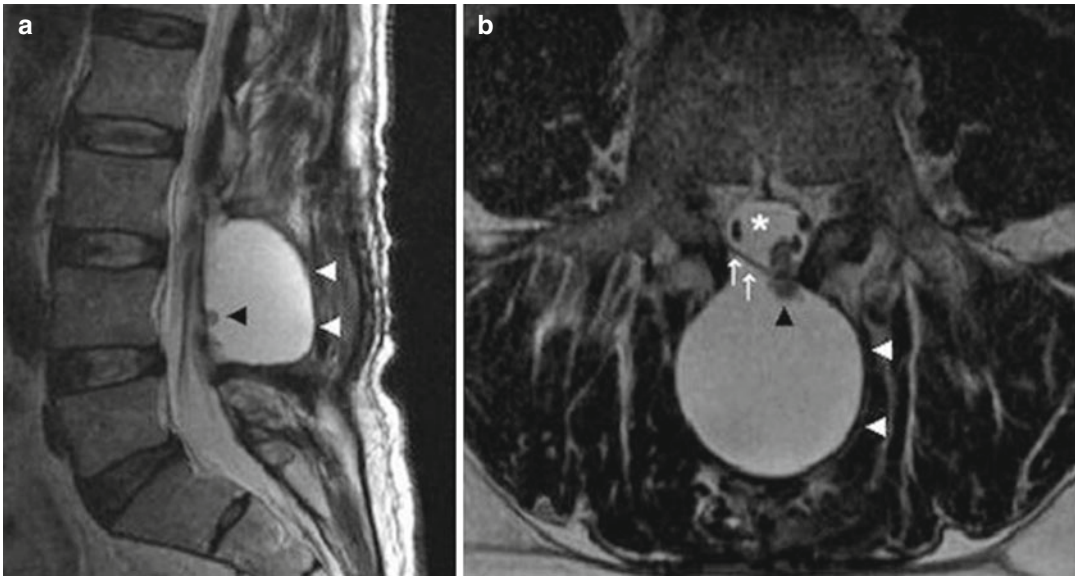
Postoperative T2-weighted MRI of the lumbar spine in the sagittal plane (a) and the transversal plane (b) showing a large pseudomeningocele (white arrowheads)
